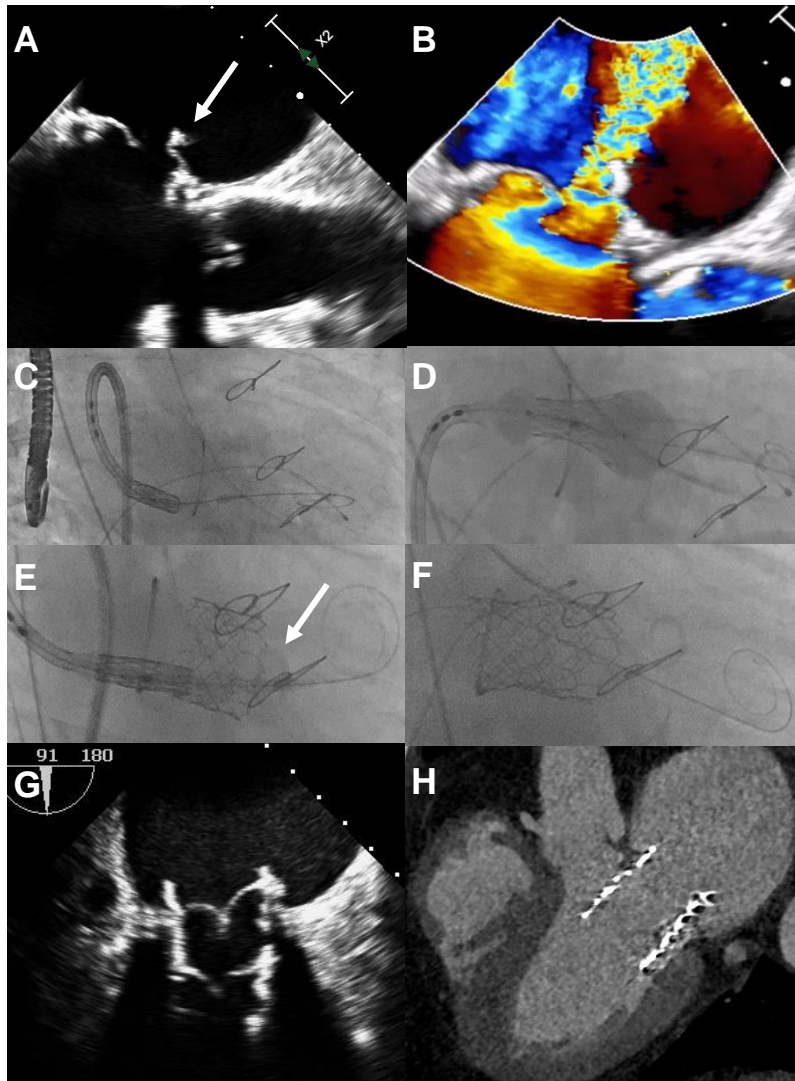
Images of mitral valve-in-valve rescue procedure in different modalities: A – perforated mitral prosthesis leaflet (arrow) in transoesophageal echocardiography (TOE); B – severe mitral regurgitation in TOE Color Doppler; C – challenges in delivery system navigation due to enlarged left atrium in angiography; D – non-uniform balloon inflation during transcatheter heart valve (THV) deployment; E – anchoring the proximal part of previous loose THV to the another THV using delivery system, stiff wire and pigtail catheter (arrow); F – the final result in angiography; G – complete expansion of the prostheses in TOE; H – no left ventricle outflow tract obstruction in computed tomography
